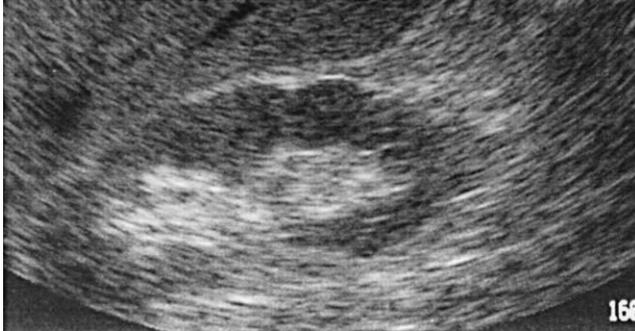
Normal right kidney on longitudinal view. Note the echogenic white Gerota's fascia, the grainy gray renal cortex, and the central echogenic pelvicalyceal structures. (From Brown DFM, Rosen CL, Wolfe RE. Renal ultrasonography. *Emerg Med Clin N Am* 1997;15:878; with permission.)
